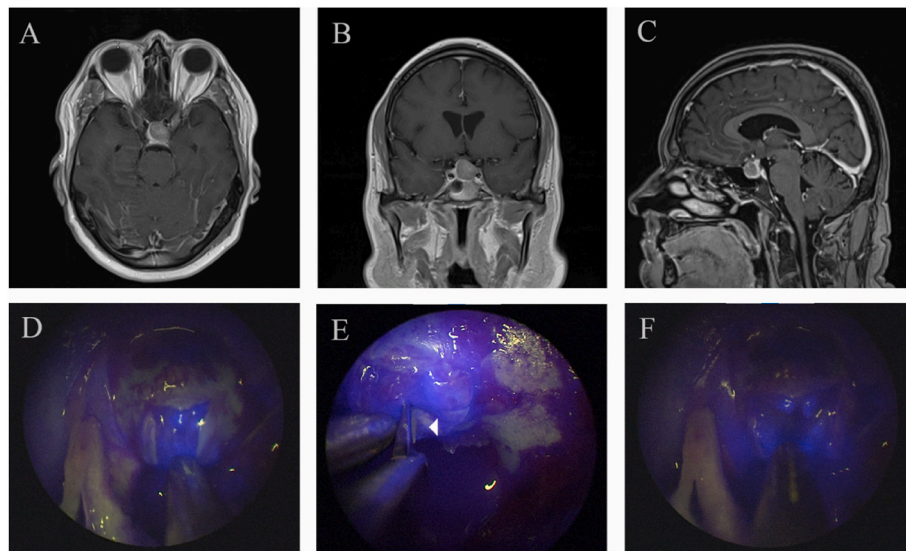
(A) axial, (B) coronal, and (C) sagittal MRI post-contrast images of a pituitary macroadenoma where the gland is pushed to the right side and is covering the sellar face. (D) shows opening of the dura and underlying hyperfluorescent pituitary gland. (E) shows sectioning of the gland to reveal the underlying hypofluorescent adenoma. (F) shows a cruciate incision of the pituitary gland and the underlying hypofluorescent adenoma.
